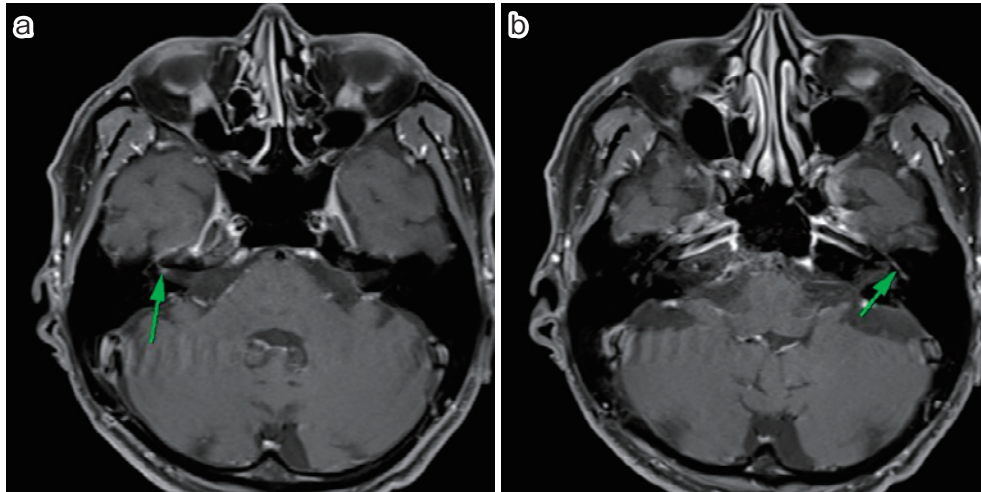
T1-weighted axial image of brain MRI with contrast enhancement
